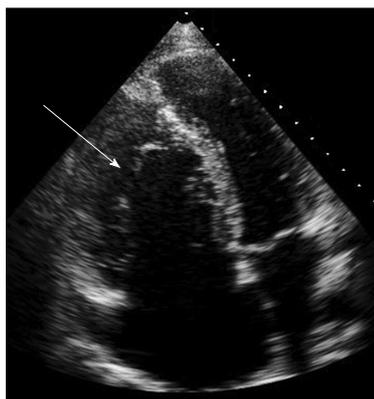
Echocardiography apical 4 chamber view showing the apically displaced tricuspid valve orifice, small right ventricle, large atrialized right ventricle and dilated right atrial.
